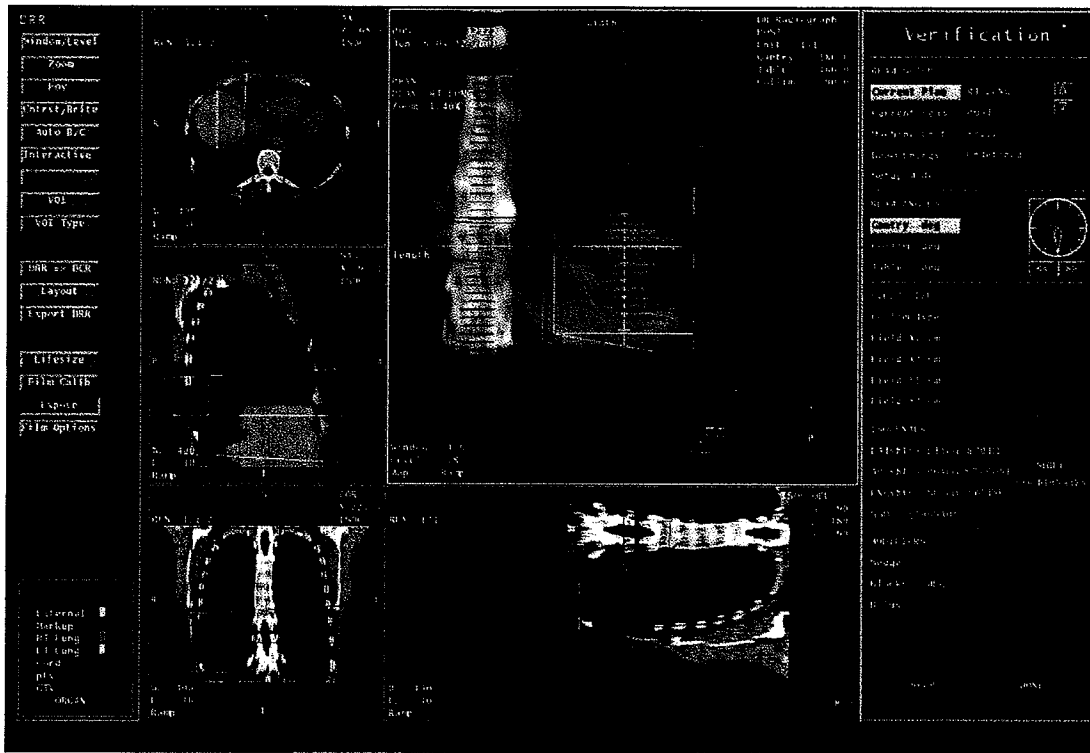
Verification: the “shift coordinates” represent the relationship between the isocentre and the “patient marked origin” to be used for treatment setup. All field digitally reconstructed radiographs are exported for portal verification on the linear accelerator.
